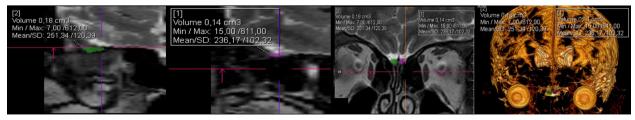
44-year-old male diabetic patient with olfactory dysfunction before HBO treatment. Three-dimensional volume measurements of the bilateral olfactory bulbs: 140 mm³ on the left side, 180 mm³ on the right side. Right olfactory bulb, sagittal T2W MRI; Bilateral olfactory bulbs, coronal T2W MRI; Bilateral olfactory bulbs, three-dimensional (3D) Volume rendering (VR) T2W MRI, respectively.
